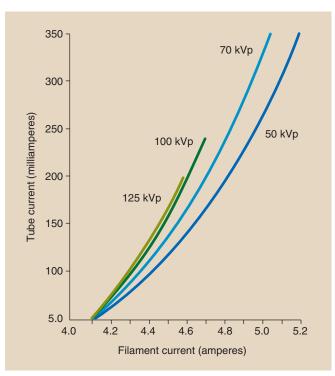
The x-ray tube current is actually controlled by changing the filament current. Because of thermionic emission, a small change in filament current results in a large change in tube current.
